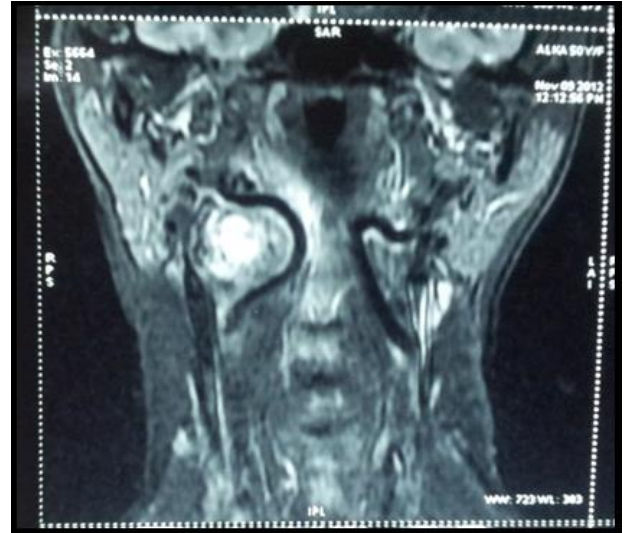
(MRI neck showed a hypervascular mass)
